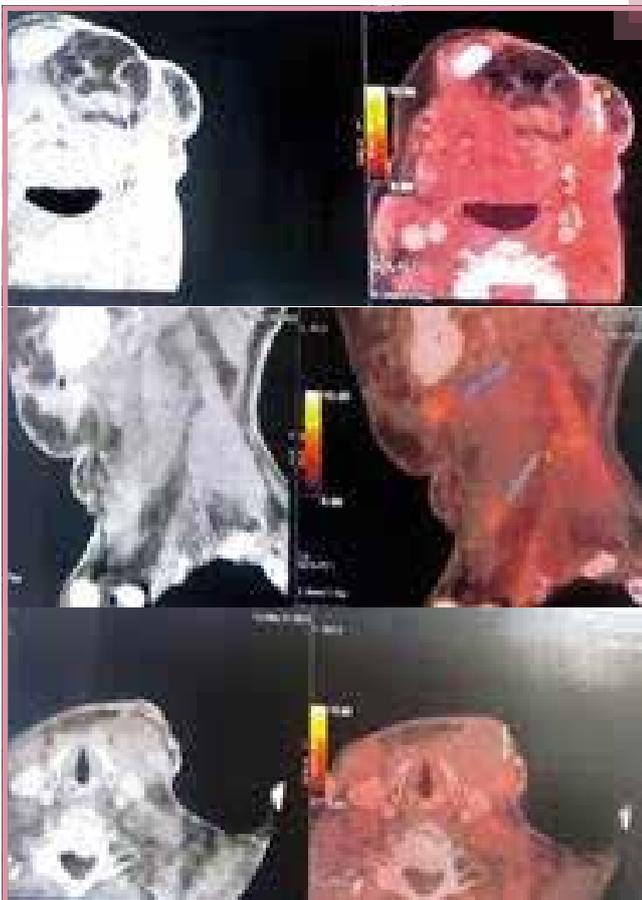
FDG avid left level 1b and level 3 node
